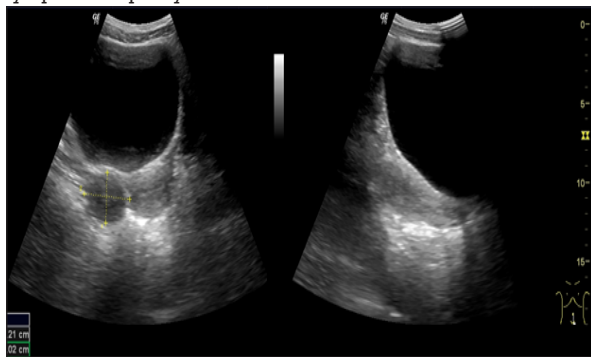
Ultrasound pelvic organ showing hypoechoic lesion in pelvis right adnexa. 1b Normal uterus appearance in ultrasound pelvic organs.
